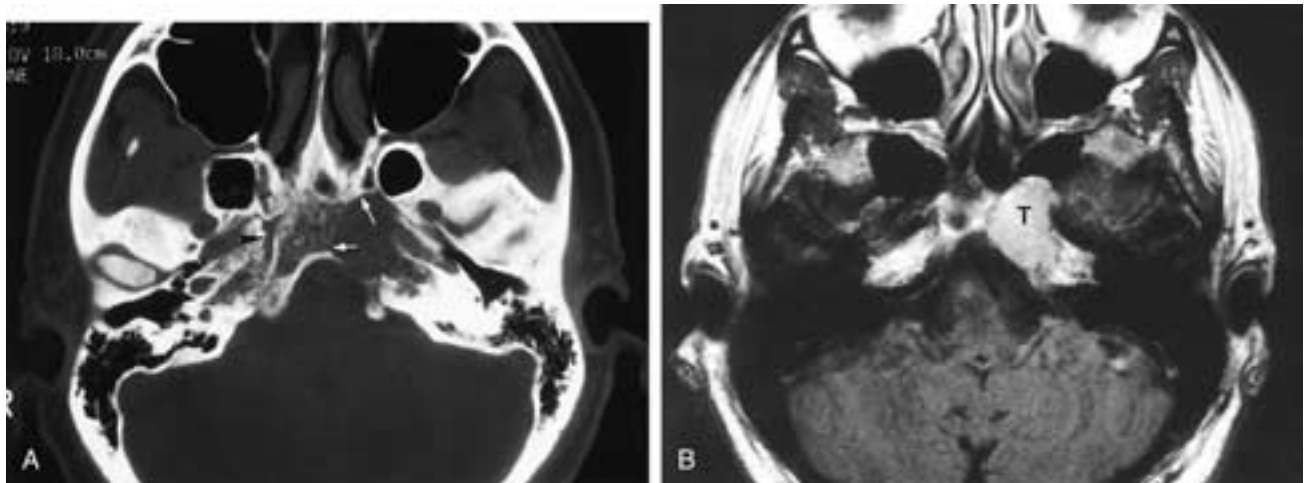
Chondrosarcoma arising in the foramen lacerum and petroclival fissure. A, CT bone scan algorithm shows a fairly smooth margin (*arrows*) of tumor arising in the region of the foramen lacerum. Note the normal foramen lacerum (*black arrowhead*) on the opposite side. B, T1-weighted postcontrast image. The tumor shows intermediate enhancement. The abnormality had a lower signal intensity on the T1-weighted precontrast image and relatively high signal intensity on the T2-weighted images (not shown).
